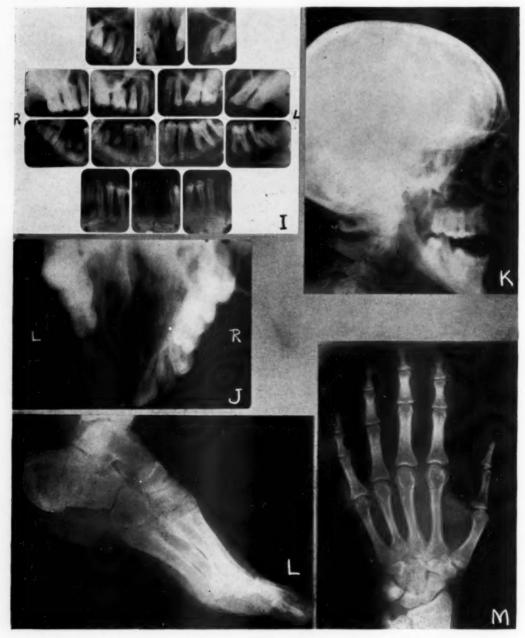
I, Full mouth x-ray series. J, Occlusal x-ray view showing bony clefts involving nasal fossa. K, Profile x-ray of skull showing maxillary osteo-deficiency. L, X-ray of ankle showing normal osteogenetic development. M, X-ray of wrist showing normal osteogenetic development.
